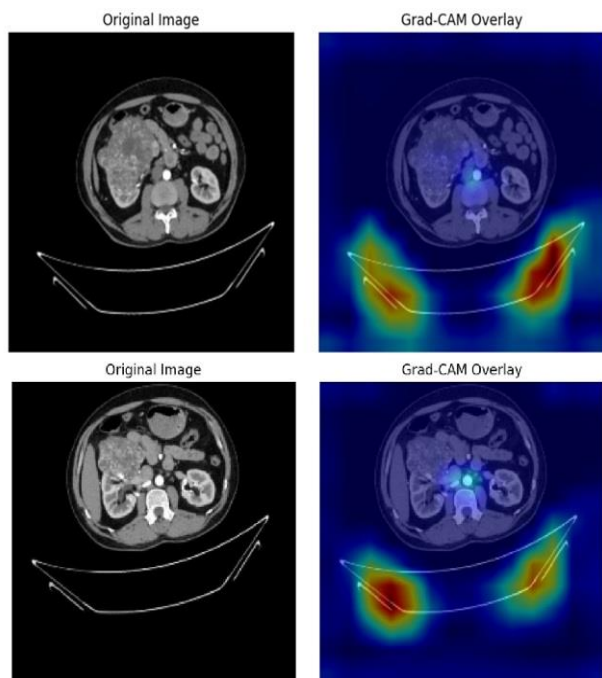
Grad-CAM visualizations of kidney CT images using the proposed Explainable MedAttn-ResNet50 model
